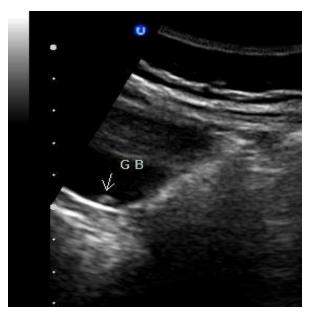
Transverse ultrasound scan of the gallbladder (GB) of same patient showing the gallstone (arrow)
